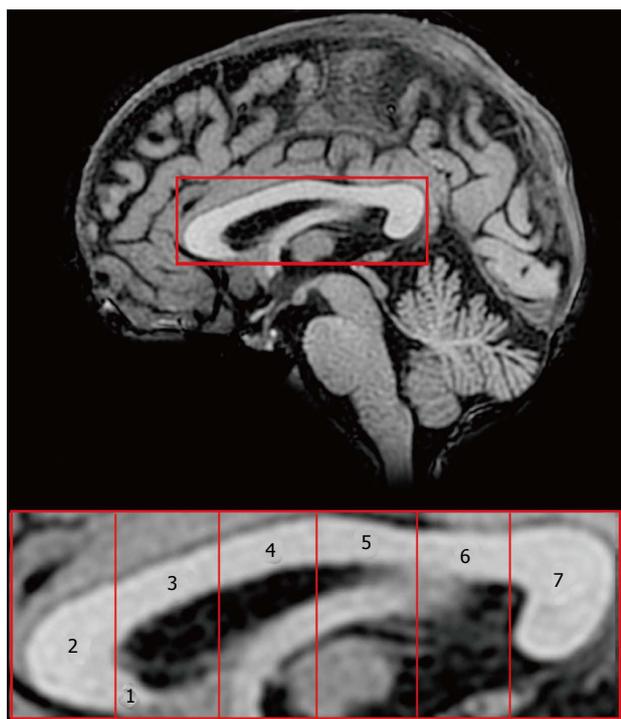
Subdivisions of the human corpus callosum. Midsagittal magnetic resonance image of the corpus callosum (above) and its seven anatomical regions according to Witelson^[8]. Region 1: Rostrum; 2: Genu; 3: Anterior midbody; 4: Central midbody; 5: Posterior midbody; 6: Isthmus; 7: Splenium. Both images are oriented in the Talairach space, where the origin of X, Y and Z axes coincides with the anterior commissure (coordinates 0, 0, 0).
